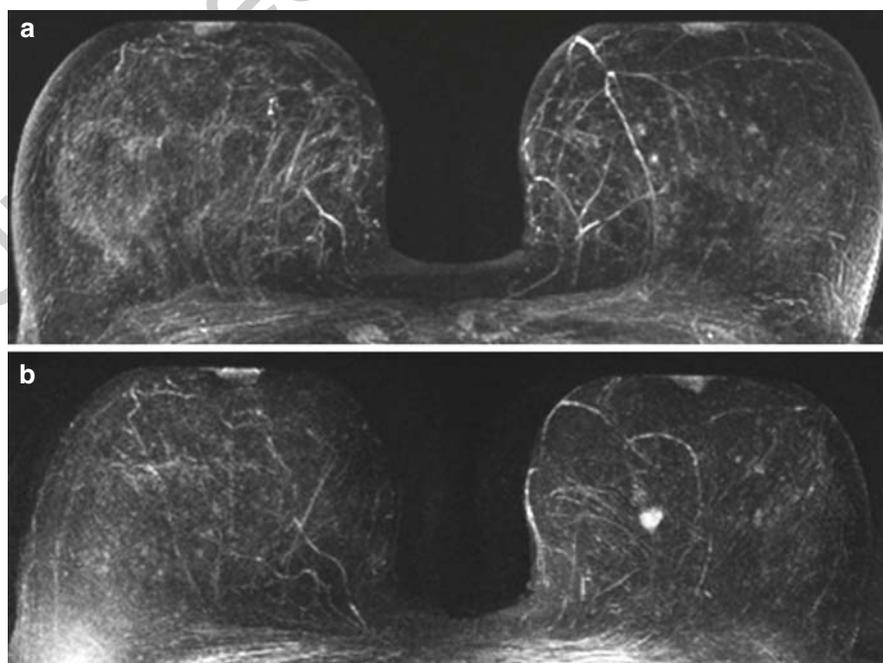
Goettinger Optipack – follow-up. MRI in a woman with high familial risk profile. MIP of subtraction images demonstrates several foci in both breasts (a). No suspicious findings were diagnosed (MRM BI-RADS 1). Eighteen months later, MRI depicts an 8 mm enhancing mass in the center of the left breast (b). This lesion was occult in mammography and ultrasound. MR-guided vacuum biopsy verified an invasive ductal carcinoma (pT1c, pN0)
